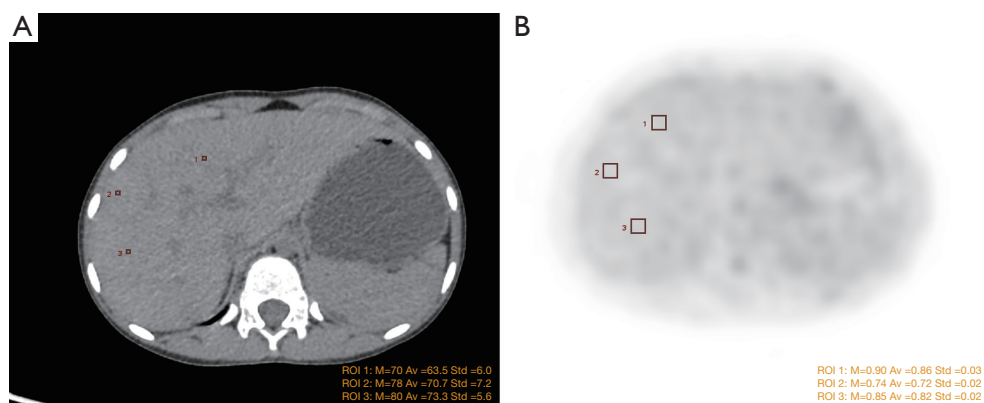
ROI selection and delineation in liver parenchyma: (A) on a CT cross-section; (B) on a PET cross-section. ROI, region of interest; CT, computed tomography; PET, positron emission tomography; M, max; Av, average; Std, standard deviation.
